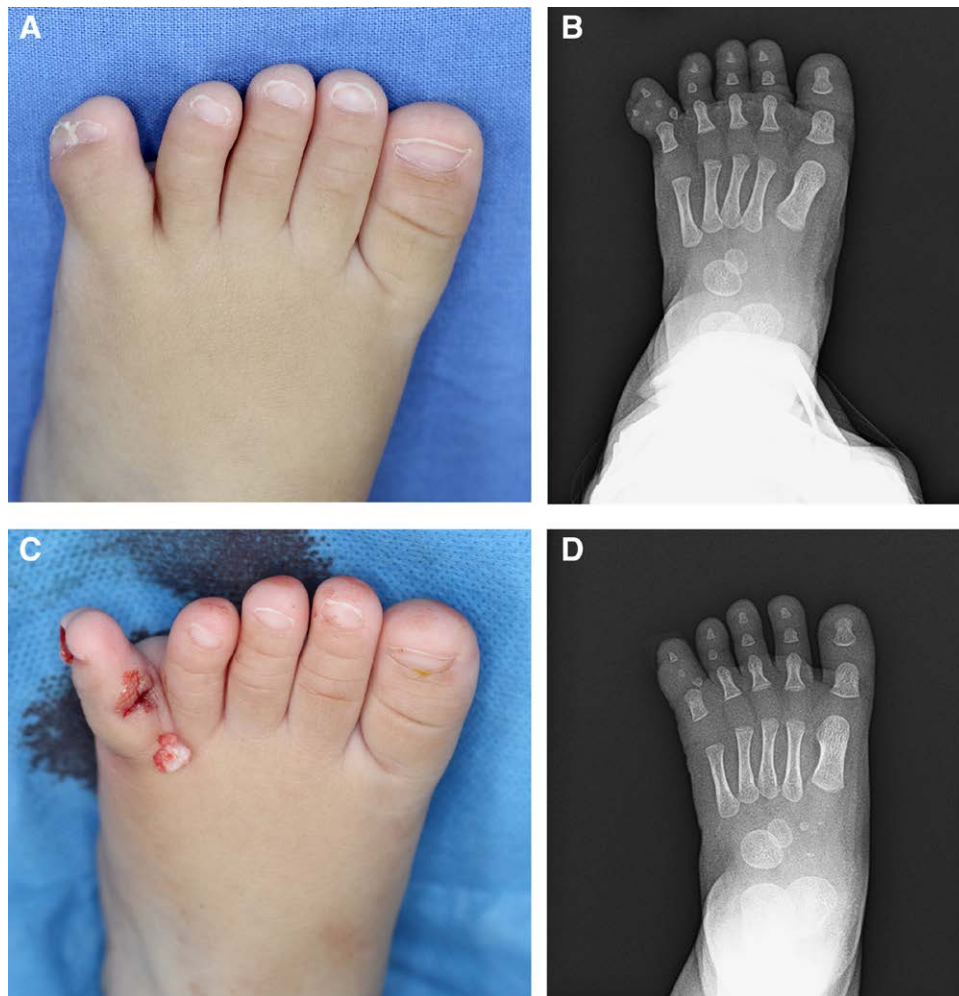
Excess bone case 4. A, Photograph of the fourth, fifth, and sixth toes. A bulge due to excess bone is seen on the medial side of the fifth toe. B, Radiograph of the fourth, fifth, and sixth toes. Taken at the same time as (A). C, Intraoperative photograph. Removed excess bone was a single bone fragment without joint cavity. The bone was split in half and half put back in place. D, Radiograph on postoperative day 11. The axis of the toe is satisfactory after surgery.
